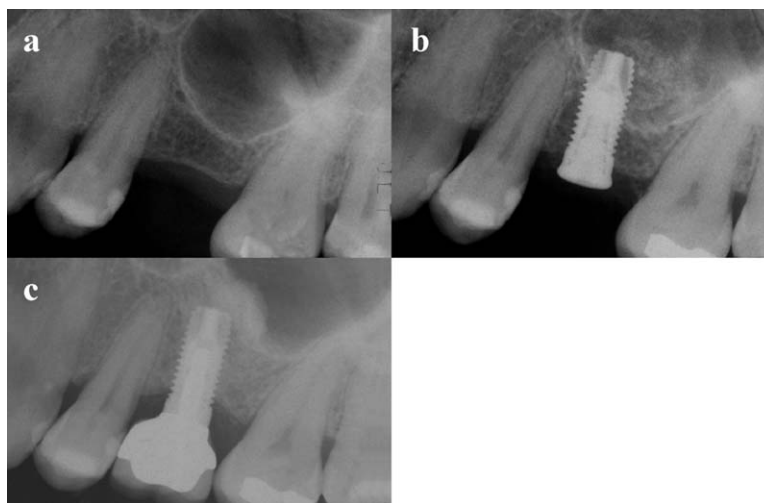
Intraoral radiographs before sinus lift elevation (a), after implant installation (b) and at 1-year post surgery (c).
